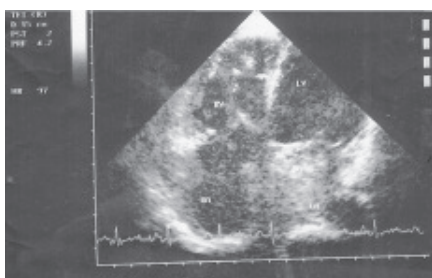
A apical four-chamber view of a patient with a large highly echogenic mass in the left atrium compatible with atrial myxoma.
